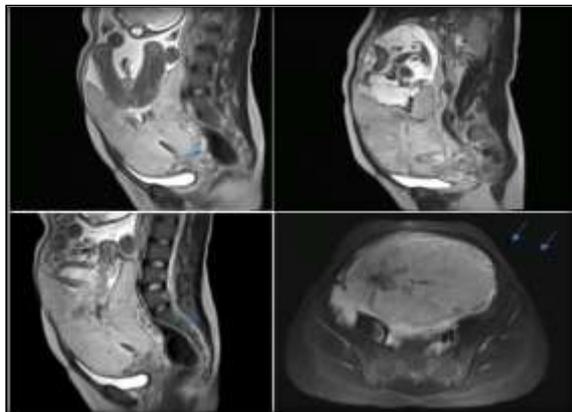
A 28 year old woman (Gravida 2) with previous history of Caesarean section. MRI T2WI HASTE sagittal and coronal images show placenta previa with (a) thinning of myometrium with loss of placenta-myometrium interface and (b) intraplacental dark bands.
